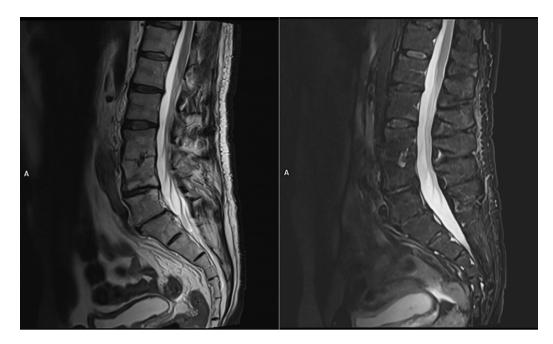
After 2 years of incidence, a follow-up magnetic resonance imaging (MRI) examination of the lumbar spine (T2-weighted sagittal images) showing lesion regression at the L3-L4 level.
